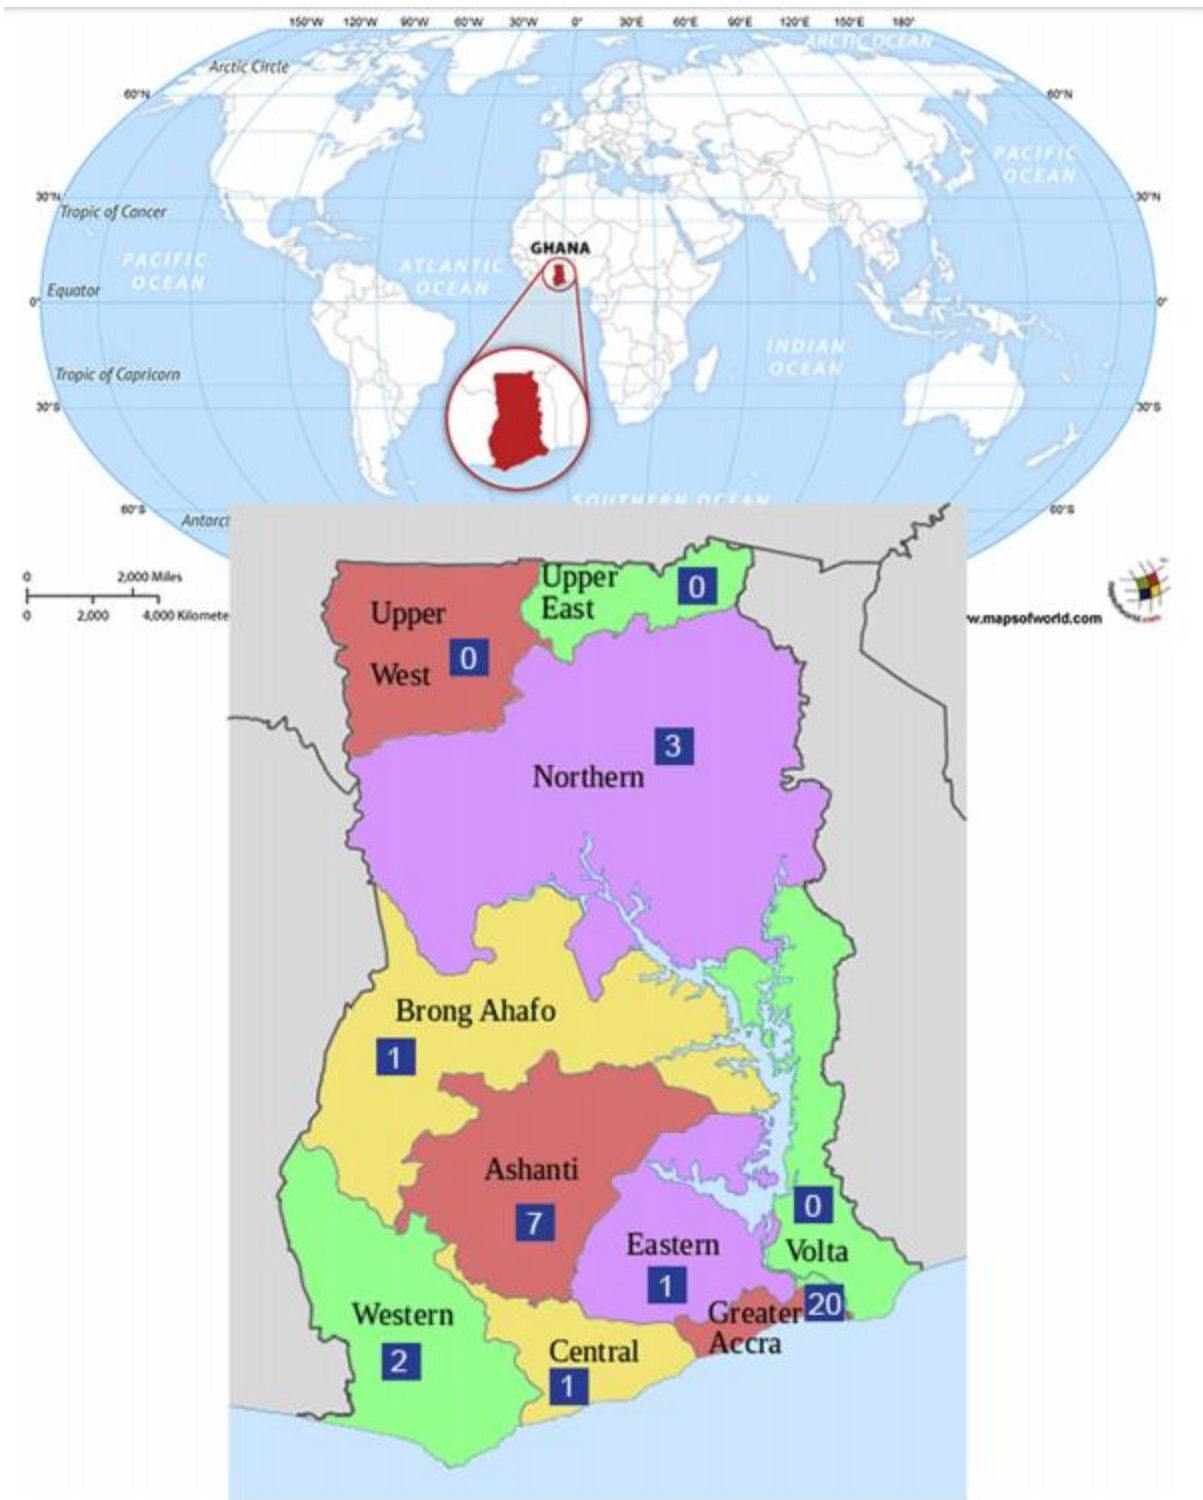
Geographical locations of the CT scanners in Ghana, 2017. CT, computed tomography.
